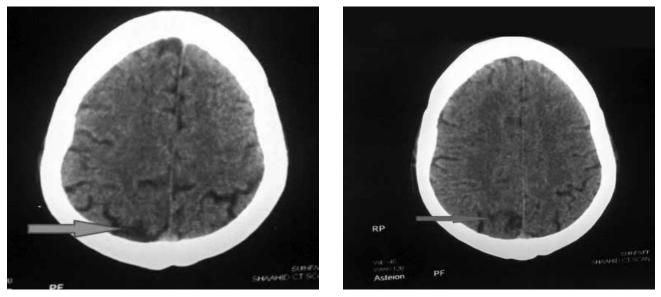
CT brain images showing patchy hypodensity at right posterior parietal cortex (arrow).
